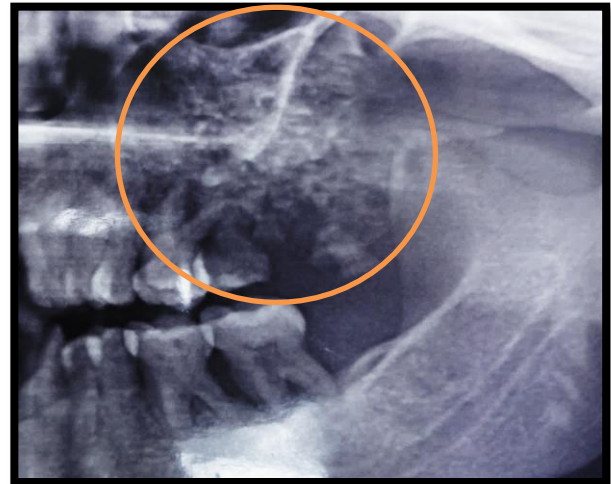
A cropped image of an orthopantomograph showing a large mixed radio-opaque radiolucent lesion on left maxilla.
